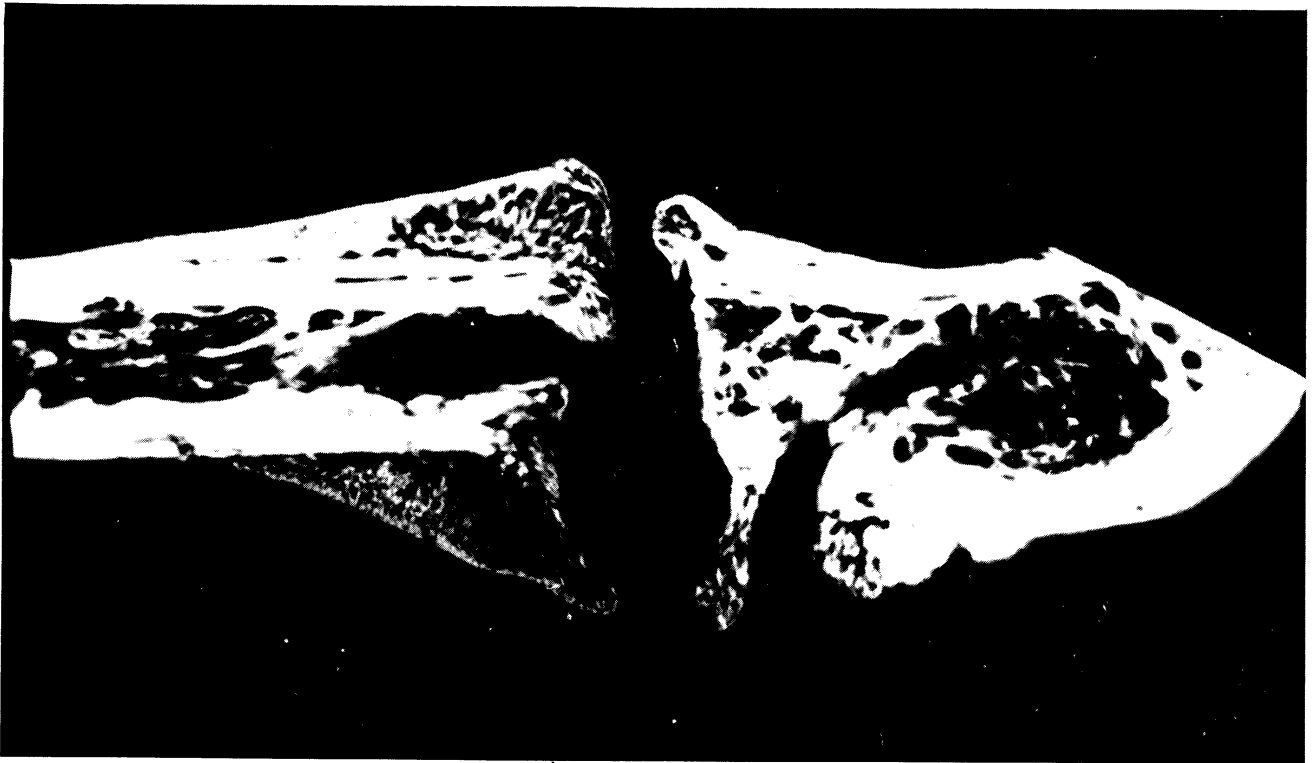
Horizontal section radiograph demonstrating obvious nonunion.
